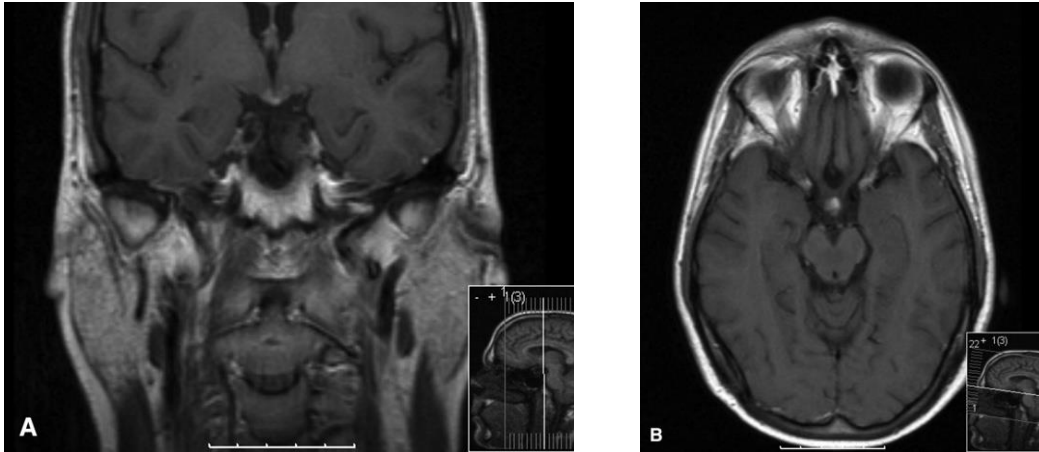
T1 weighted coronal& axial MRI showing enlargement and enhancement of the pituitary gland and stalk in tuberculosis. (Frohman et al., 2003) ;(Koszman et al., 2008
